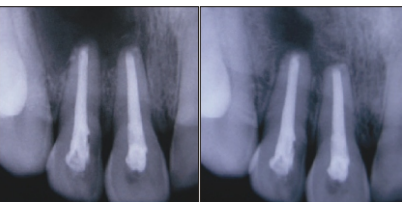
Seven days post operative radiograph Fig. 31 : Six months post operative radiograph
